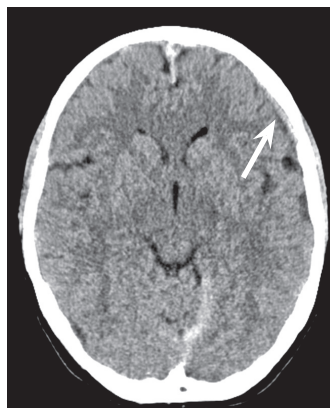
Brain computed tomography – subdural haematoma above the left hemisphere
